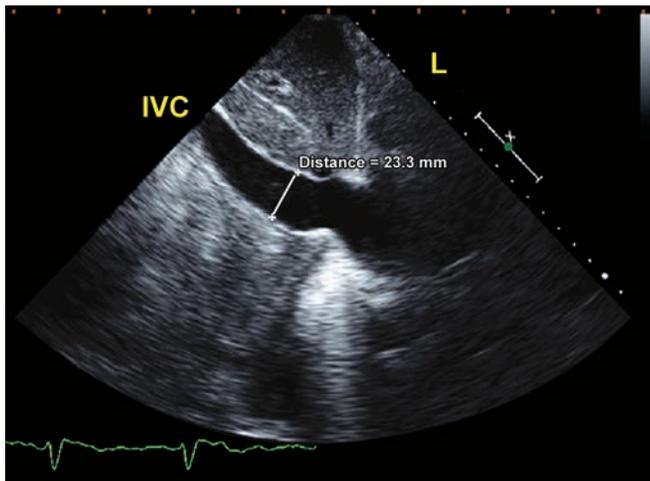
Transthoracic subcostal view. Shows dilated IVC with diameter of 23.3 mm.
